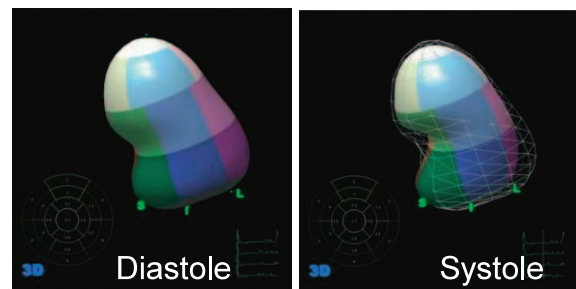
Abnormal left ventricular cavity reconstructed by 3-D measurement of echocardiography in the subject shown in Figure 10 and 11.
